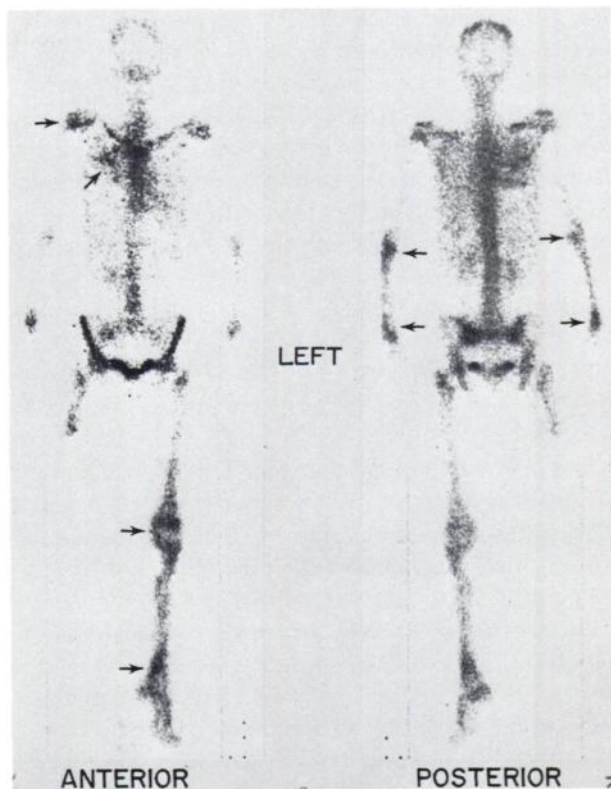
Whole-body scan (anterior and posterior view) performed 3 hr after injection of 8 mCi of ^{99m}Tc -polyphosphate showing increased uptake in region of density seen on x-ray and around joints of wrists, elbows, shoulders, hip, left knee, and left ankle.
